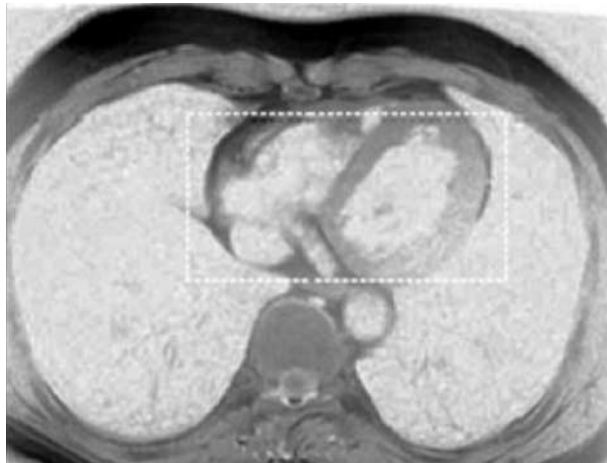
Axial MRI image of lungs with heart contained within a specified rectangular area.
